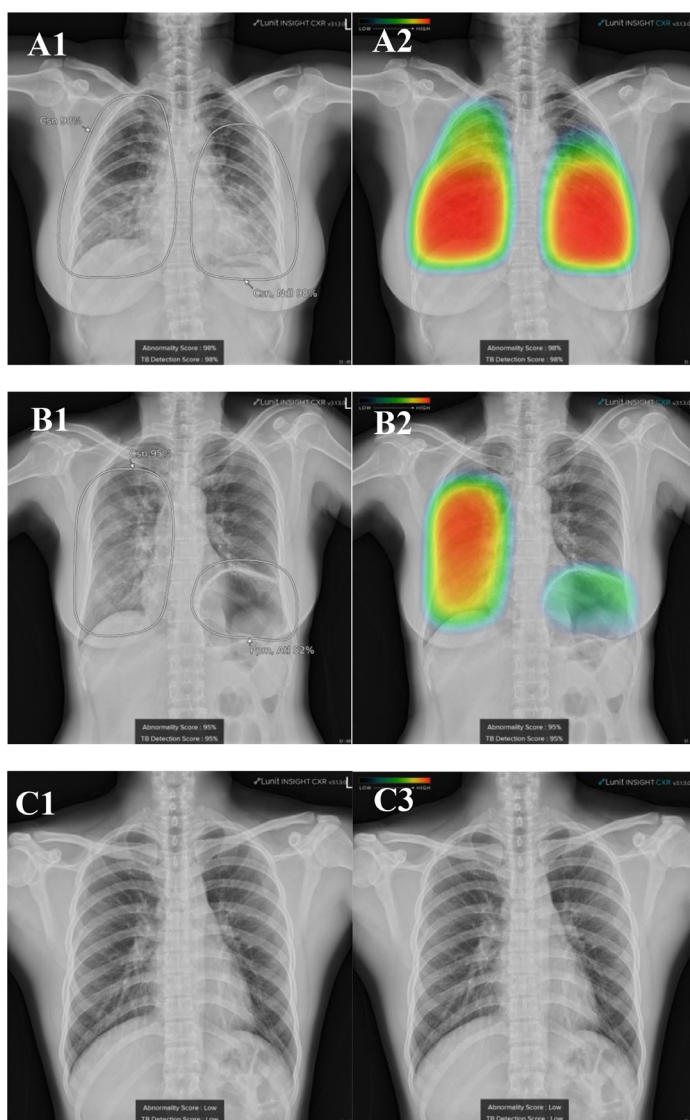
Chest radiographs with AI interpretation of three different patients. (A1 and A2) The patient diagnosis in red categories with an abnormality score of 98.56% from AI chest radiographs showed that she had pneumonia. (B1 and B2) The patient diagnosis in yellow categories with an abnormality score of 95.11% from the AI chest radiograph showed that she had pneumonia. (C1 and C2) The patient diagnosis in green categories with an abnormality score of 3.54% from AI chest radiograph showed he had pneumonia.
